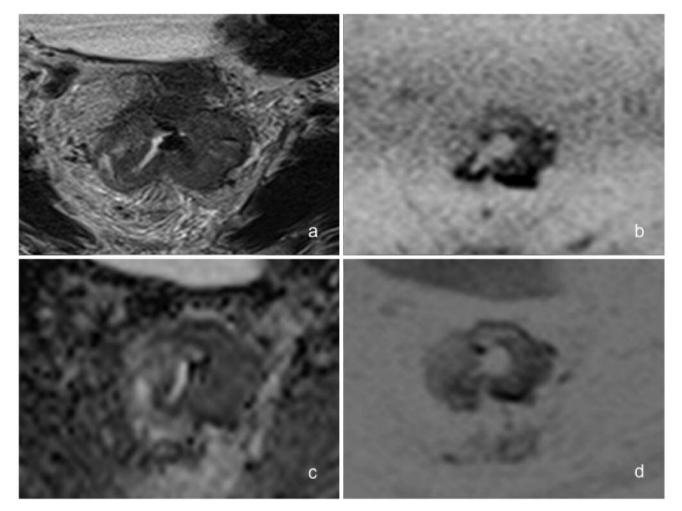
Imaging of a 56-year-old man with rectal cancer after chemoradiation (regression grade 2). a: On 2D axial T2-weighted sequence the tumor with soft-tissue signal intensity and invasion of the mesorectal fascia can be seen. b: b2000 Diffusion-weighted imaging (DWI) depicts high signal intensity of tumor, which suggests poor response to therapy and residual tumor. c, d: Apparent diffusion coefficient map and b800 DWI.
